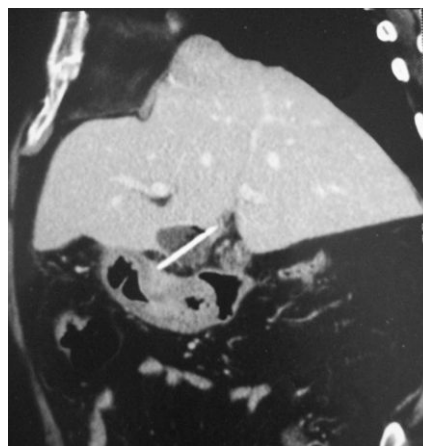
Abdominal computed tomography scan revealing the hepatic mass and the straight, hyperdense image, in contact with the thickened duodenal wall.
